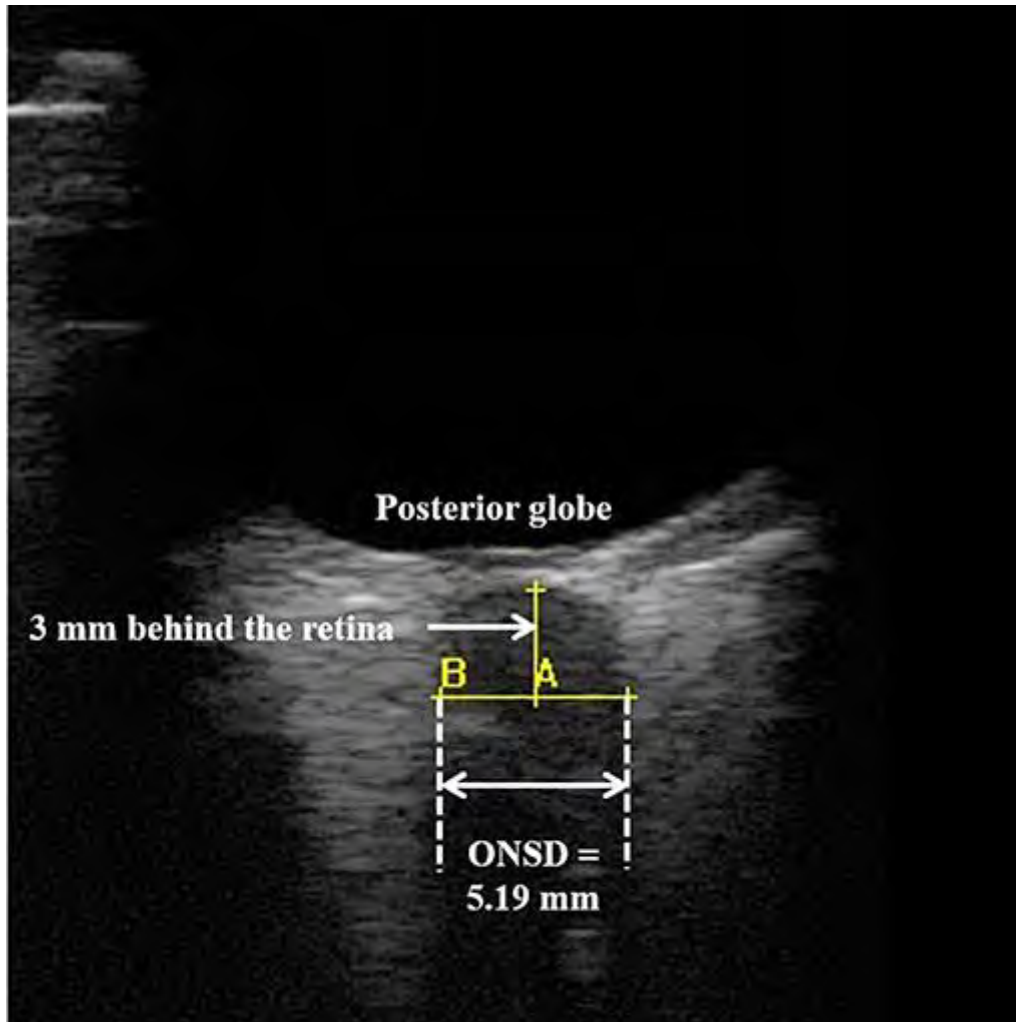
Two-dimensional ocular ultrasonography. Optic nerve sheath diameter (ONSD) was measured 3 mm behind the posterior globe.
